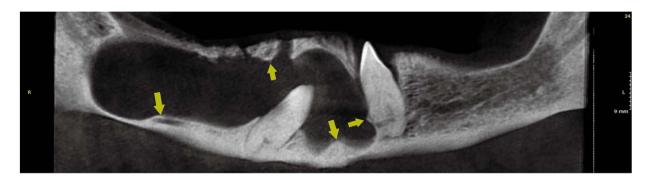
Odontogenic keratocyst from the angle of the right mandible extending to the opposite side. Panoramic reconstructed cone-beam computed tomographic image with 2-mm thickness shows scalloped borders (arrows).
